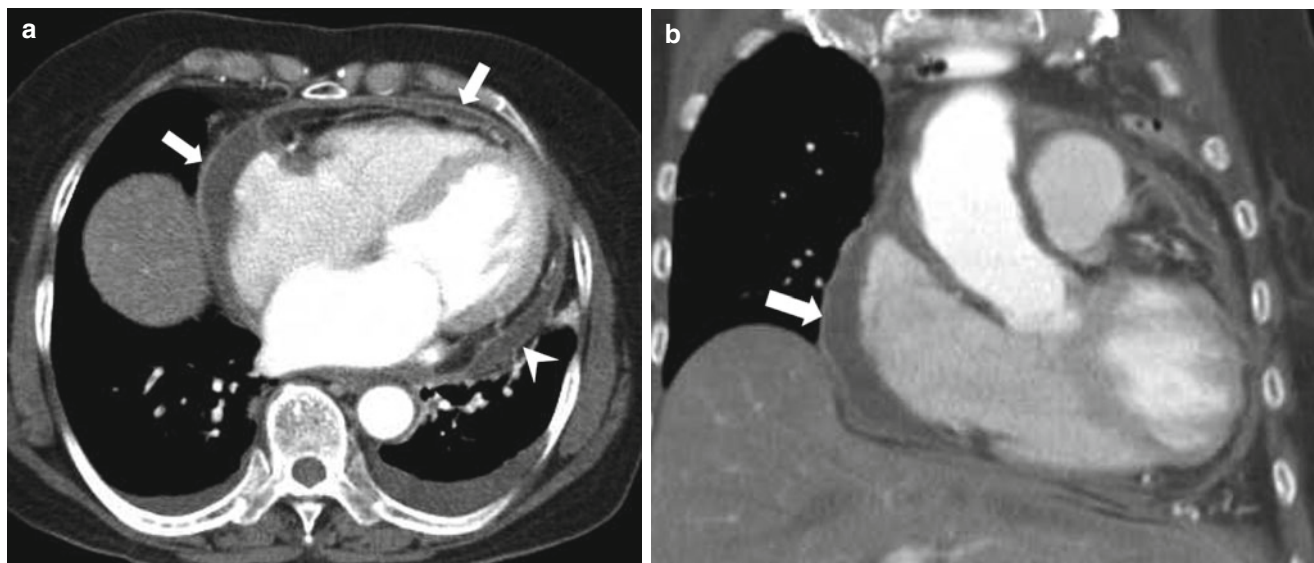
Infectious (tuberculosis) pericarditis. Axial (a) and coronal (b) chest CT images show thickened and enhanced pericardium (arrows), separation of epicardium and pericardium, moderate amount
